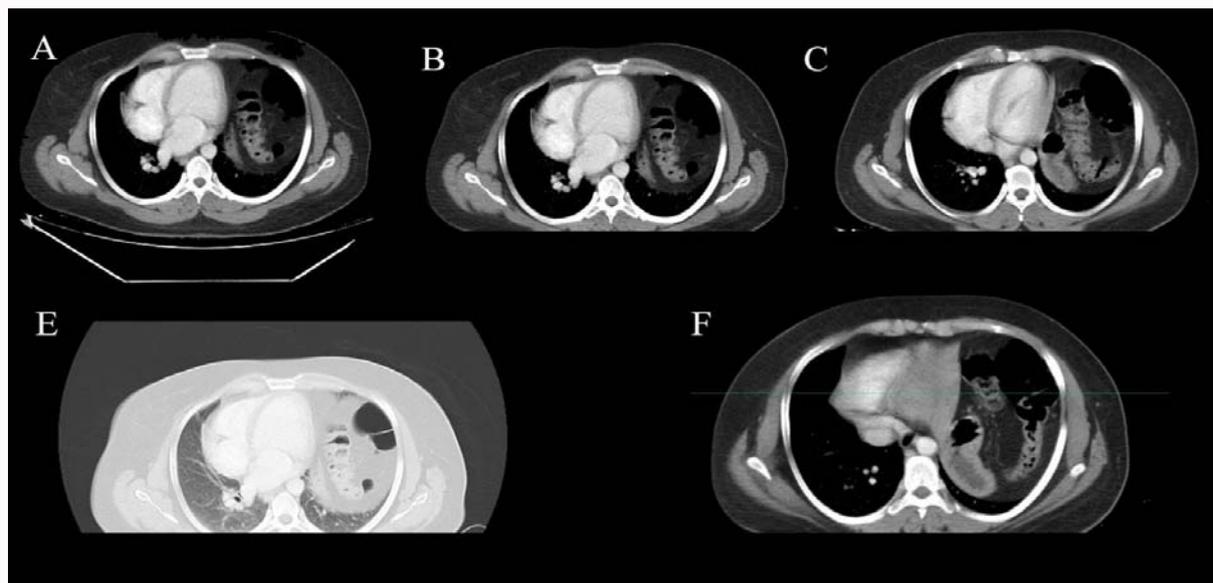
CT-scan of the chest with IV and oral contrast show colon and omentum. Small intestine in the chest.
